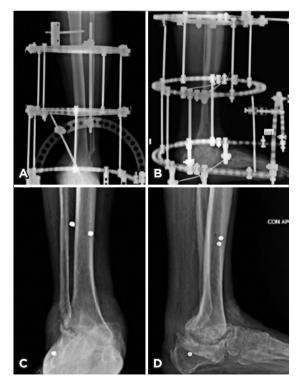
Diabetic patient with CN and concurrent osteomyelitis due to pseudomona. Immediate and last follow-up visit postoperative radiographs depicting good alignment.
